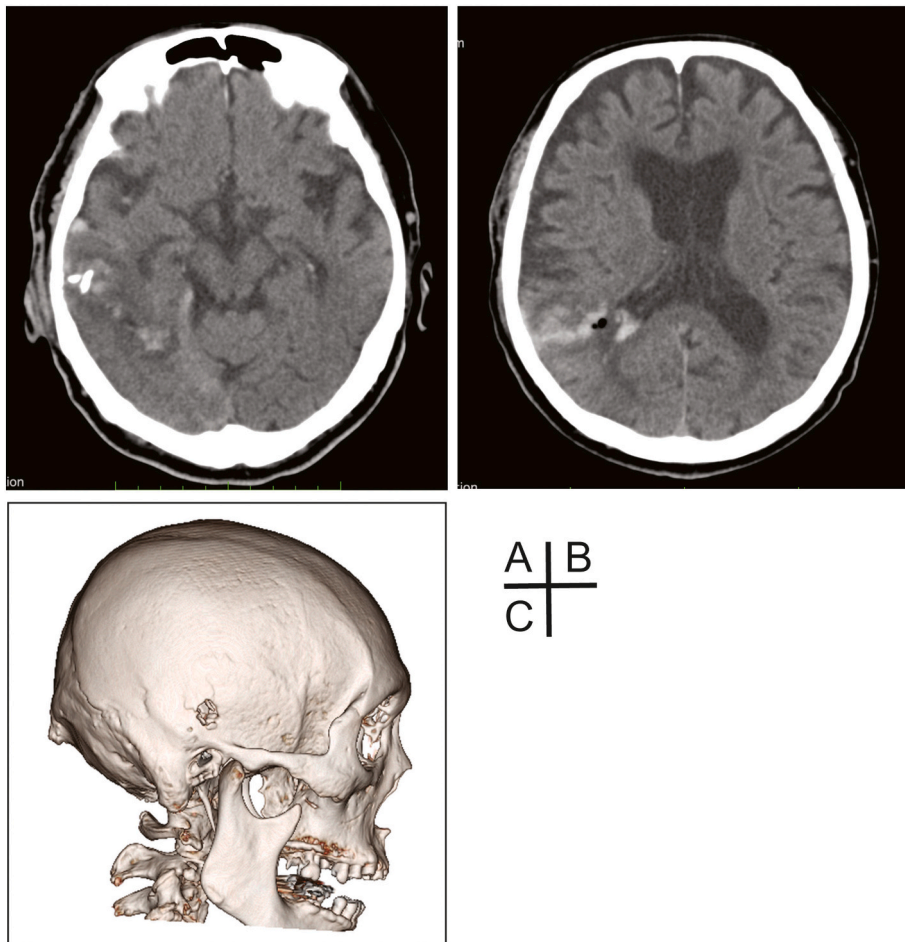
(A) Head CT without contrast at presentation demonstrating tiny pieces of bone fragments inside the brain, as well as (B) right temporal subcortical hemorrhage and pneumocephalus. (C) 3D-CT bone image demonstrating penetrating bone fracture in the right temporal bone.
